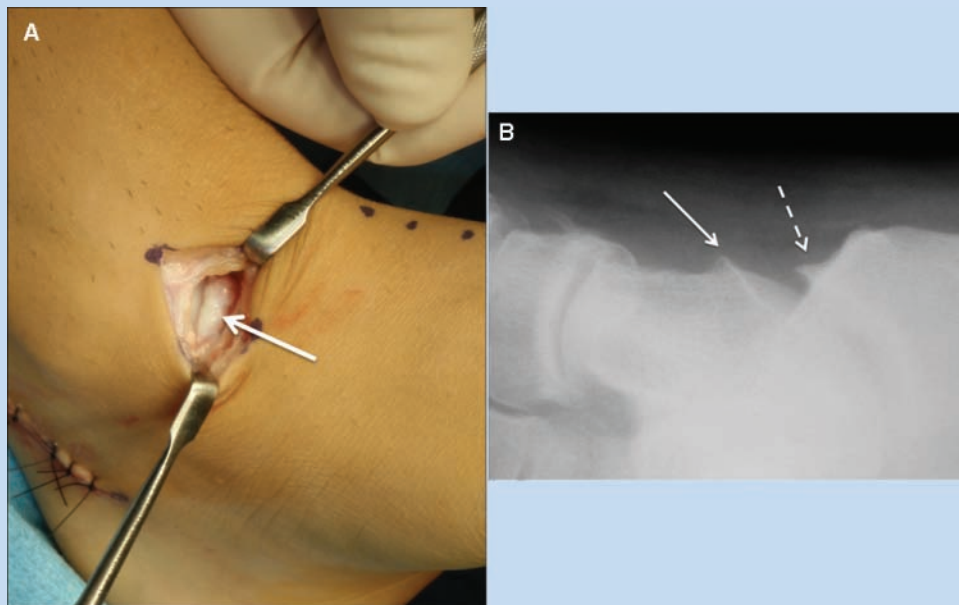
A, large spur along the leading edge of the medial talar facet in a teenage female gymnast (solid arrow). She also had a flexor hallucis longus tendon release and open reduction internal fixation of a navicular stress fracture. B, oblique radiograph of the foot in patient in panel A. Large talar (solid arrow) and tibial (broken arrow) spurs medially.
